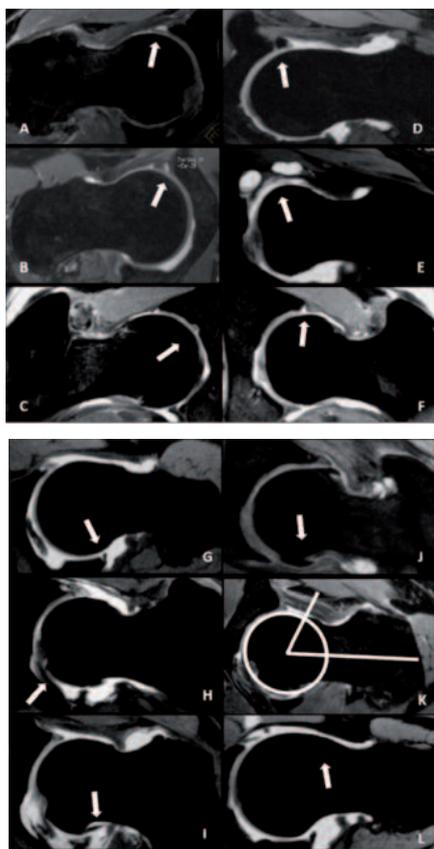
MRI appearance of normal and pathologic features.
